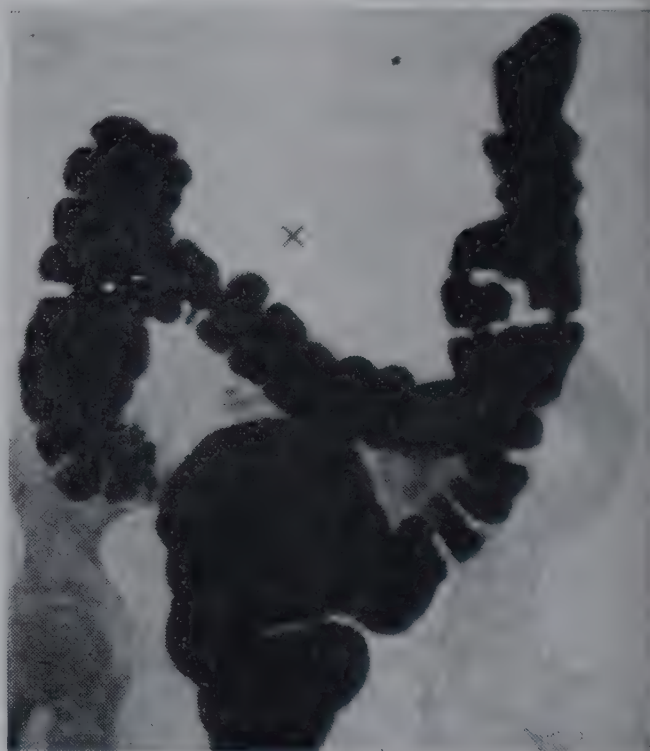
X-ray photograph of normal large bowel completely filled. (After Barclay.)
